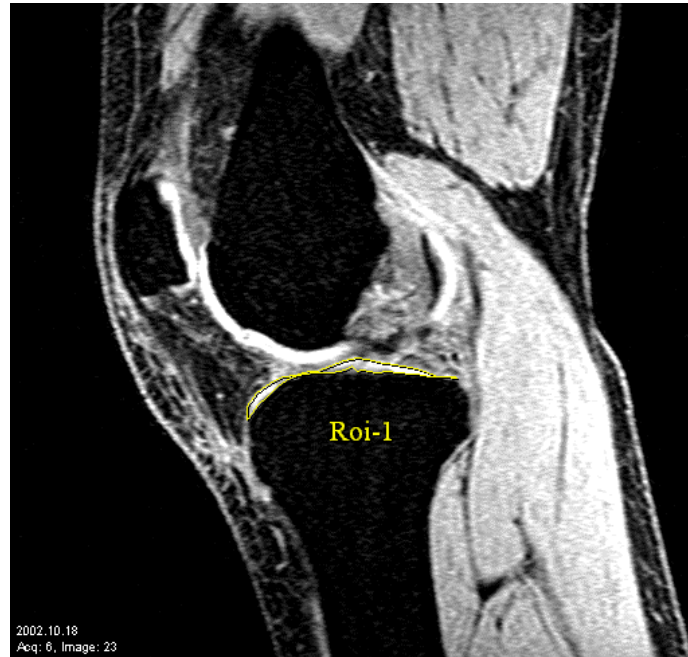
MRI of the Knee in Sagittal Plane, Tibial Cartilage Manually Segmented by Clinician
